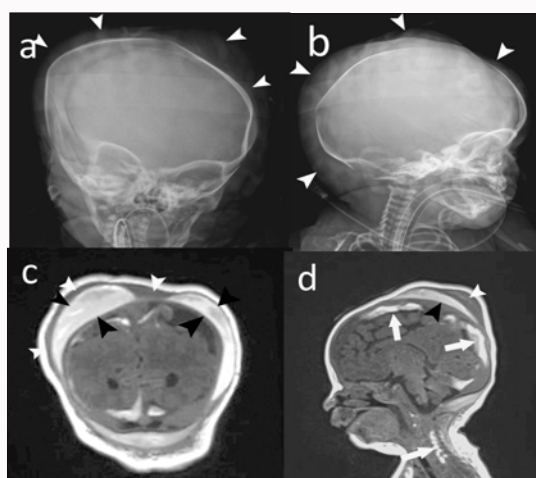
Anteroposterior (a) and lateral (b) skull radiographs and coronal (c) and sagittal (d) MR images, showing marked soft tissue swelling (arrowheads in a, b) due to extensive SGH (white arrowheads in c, d) and bilateral cephalhematomas (black arrowheads), as well as parietal, occipital and cervical spine subdural hematomas (white arrows).
